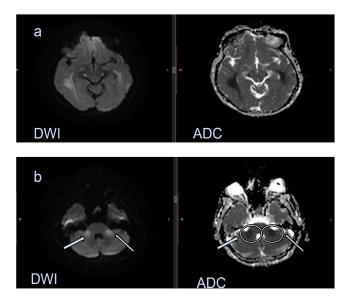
(a) Diffusion restriction in the white matter tract on a DWI and ADC MRI images.
